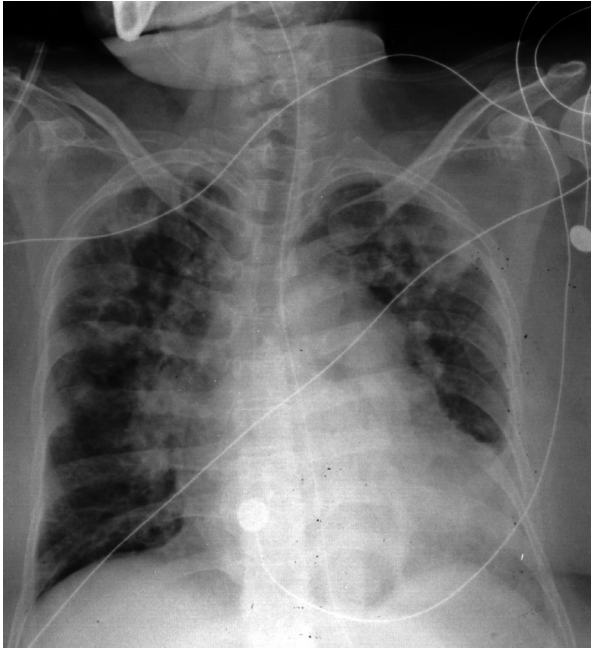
Chest radiography showed multiple cavitary infiltrates in bilateral lung fields. Enlarged cardiac silhouette, bilateral engorged hila and widened carinal angle are also noted.
